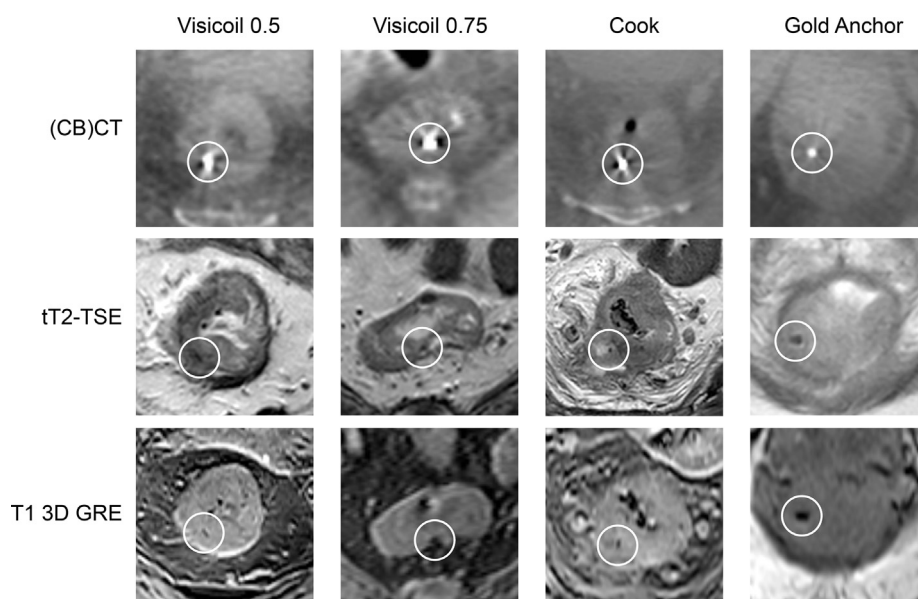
Examples of fiducials shown on (CB)CT and corresponding MRI sequences.
